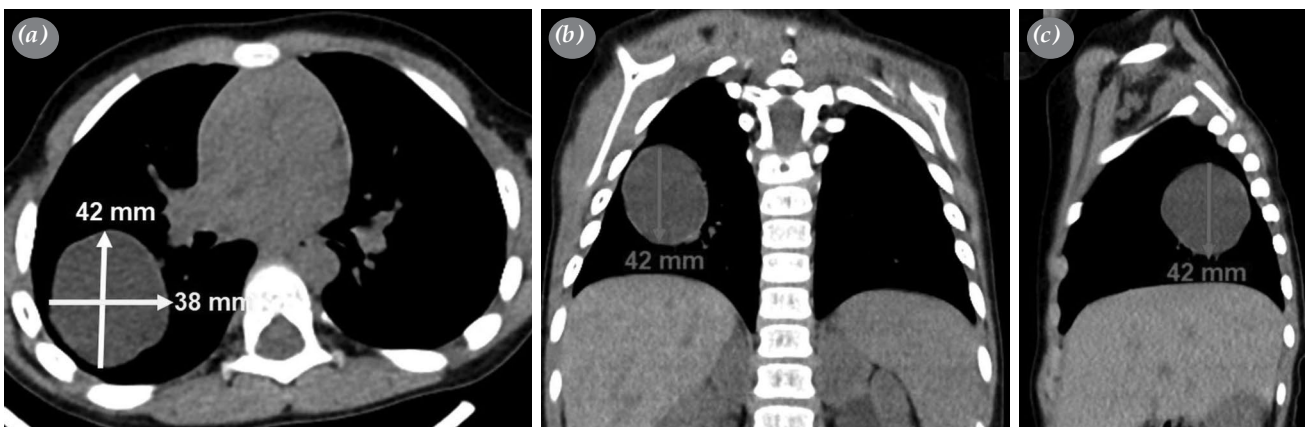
Considering the date of birth of a three-year-old male patient as the onset of the hydatid cyst, (a) axial, (b) coronal, and (c) sagittal computed tomography sections obtained 1,202 days later are shown. The volume of the cyst was measured to be 35057 mm^3 . In this case, the doubling time for the pulmonary hydatid cyst was calculated as 75 days, based on the contamination at birth (1 mm diameter). The doubling time was calculated to be 23 days if the time of infection of the cyst was assumed to be one year ago, and 46 days if it was assumed to be two years ago.
